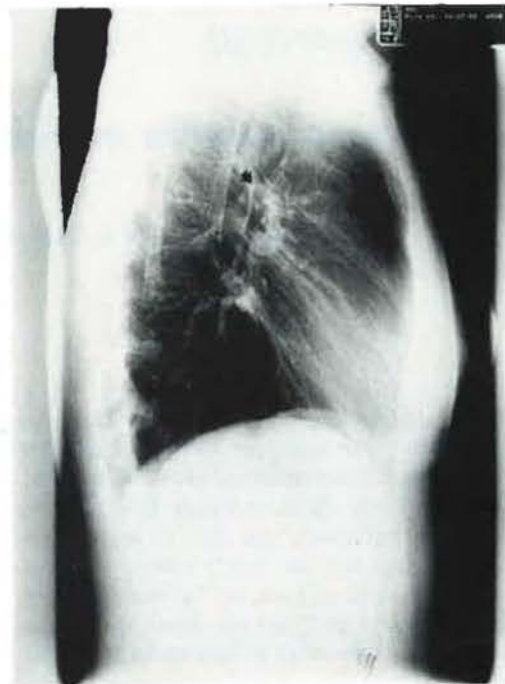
Lateral roentgenogram with normal opening of right upper lobe (RUL) (arrow).
